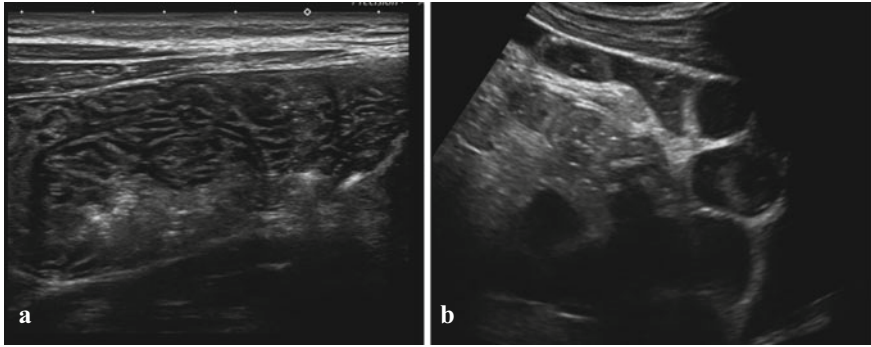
a Typical sonographic appearance of jejunum, with multiple mucosal folds filling the collapsed lumen, giving a “fish bone” pattern. b Fluid filled loops of ileum, showing minimal mucosal folds
